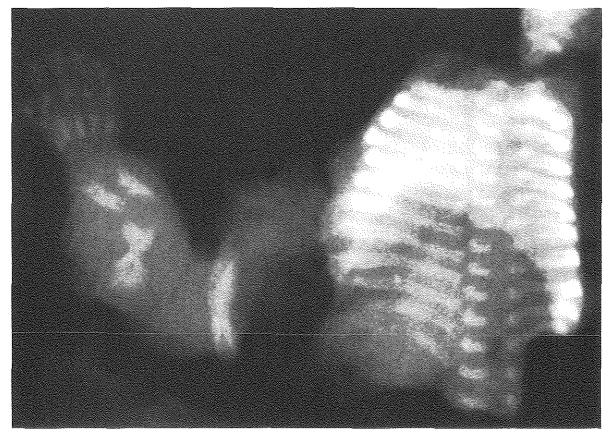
Detail of the soft-tissue radiograph of the second fetus showing the thorax and the left arm. The wide proximal and distal ends of the humerus are clearly visible. The ribs are short and broad.
